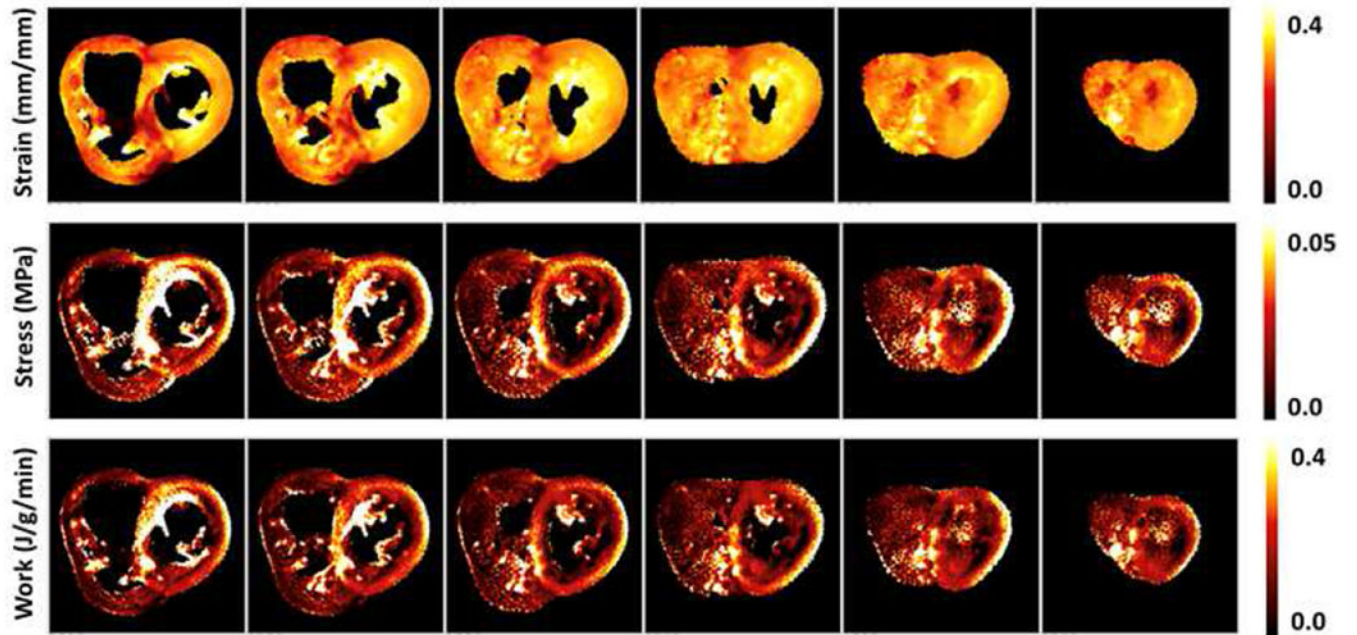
Five slices in MRI format color coded for stress (MPa). Note: 1 megapascal [MPa] = 1 newton/millimeter<sup>2</sup> [N/mm<sup>2</sup>].
